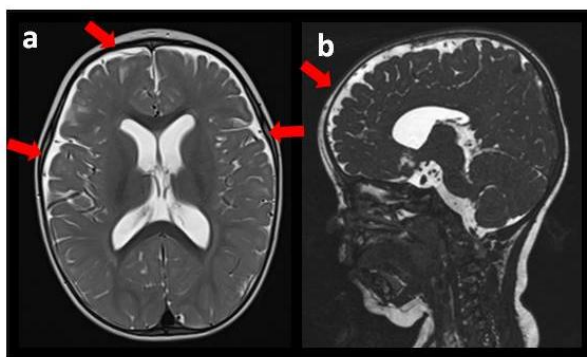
The magnetic resonance image (MRI) axial (a) and sagittal (b) T2-weighted images of a 25 month-old male are presented. The baby was born at 32 weeks of gestational age through a cesarean because of corioamniotitis. After the birth he had cardiac and pulmonary complications. The neurological evaluation showed an increase in the head circumference. The image shows the typical enlargement of the subarachnoid spaces in the frontal and temporal regions (red arrows) in infants with benign external hydrocephalus, in this case associated with a moderate increase in ventricular size.
